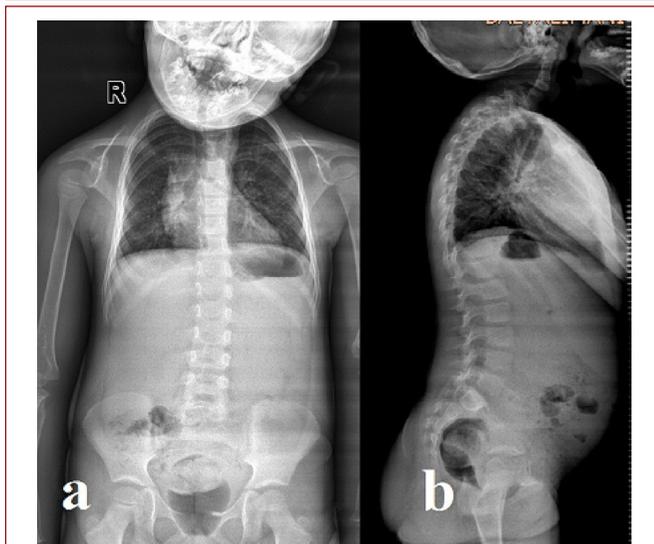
a) Preoperative anteroposterior X-ray
